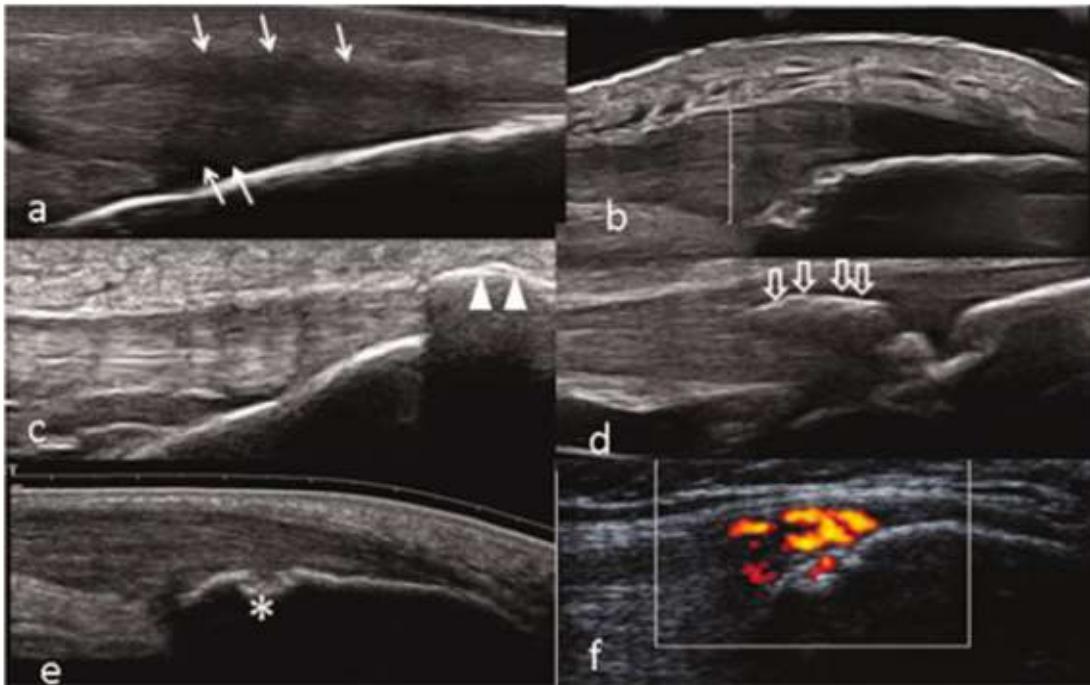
The elementary components are as follows: a, hypoechoogenicity (white arrows indicate increased thickness with blurring of the tendon margins); b, increased thickness of tendon insertion (white line); c, enthesophyte (the step up of the bony prominence at the end of the normal bone contour is marked with white arrowheads); d, calcifications (the hyperechoic focus consistent with calcific deposit is marked by open arrows); e, bone erosion at the enthesis marked with an asterisk; and f, Doppler at enthesis <2 mm from the bone insertion.
